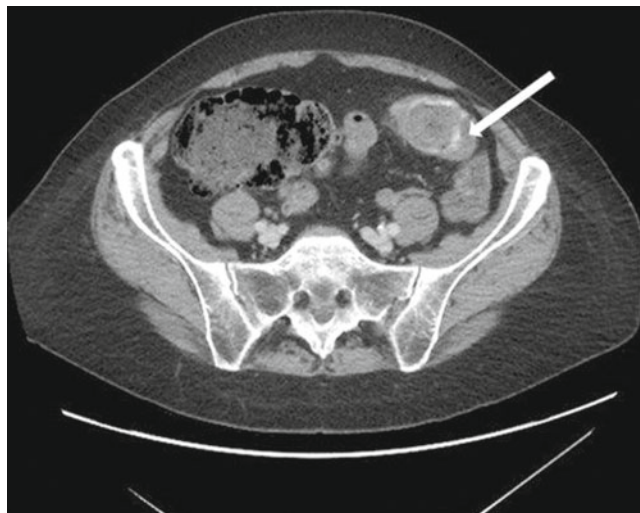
Lower GI bleeding diagnosed by contrast-enhanced computed tomographic (CT) scan. The *arrow* indicates area of active arterial extravasation seen in the descending colon
